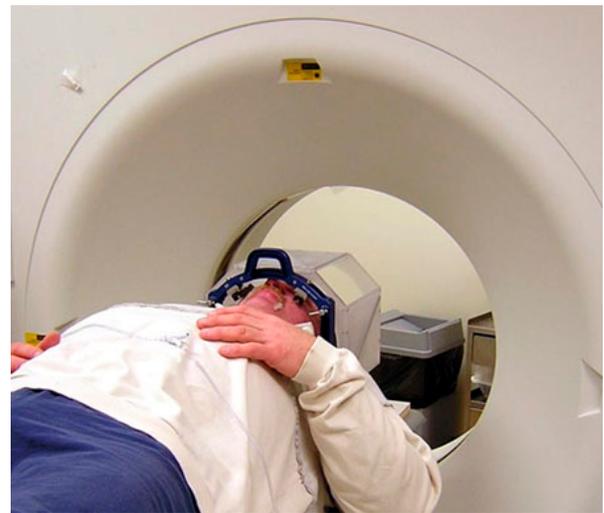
A box-shaped localizing device is placed on the frame or mask prior to CT scanning. Markers in the device are seen on the CT scan and help pinpoint the exact coordinates of the tumor or lesion.
